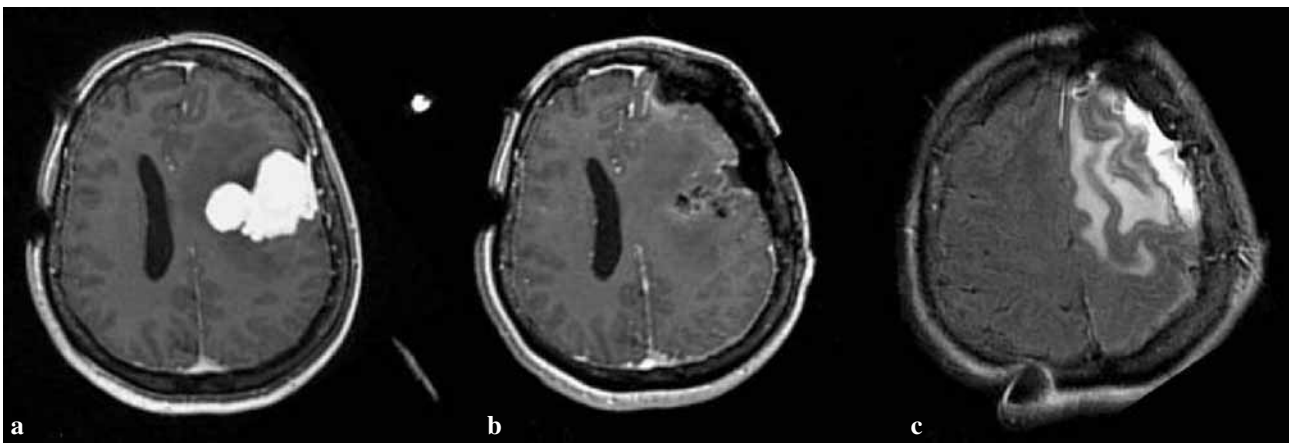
Pre-operative gadolinium-enhanced MRI showing a deep-reaching meningioma causing compression of the underlying hemisphere and ventricular system (a). Post-operative gadolinium-enhanced MRI showing complete removal of meningioma (b) and hyperintense signal of the subcortical white matter on T2 weighted images (c).
